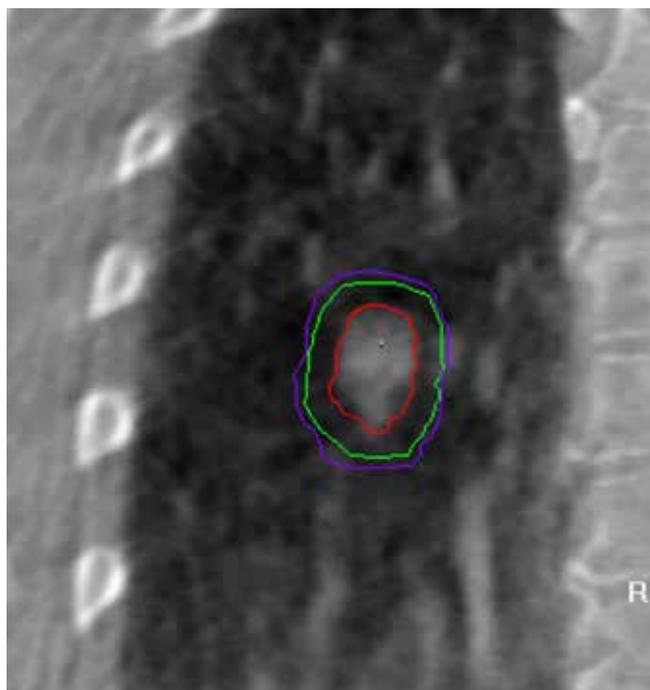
Cone beam CT images taken prior to SBRT. Red line represents the internal target volume (ITV), the green line represents the planning target volume (PTV) and the purple line represents the 95% isodose line from the radiotherapy plan included as a reference.
